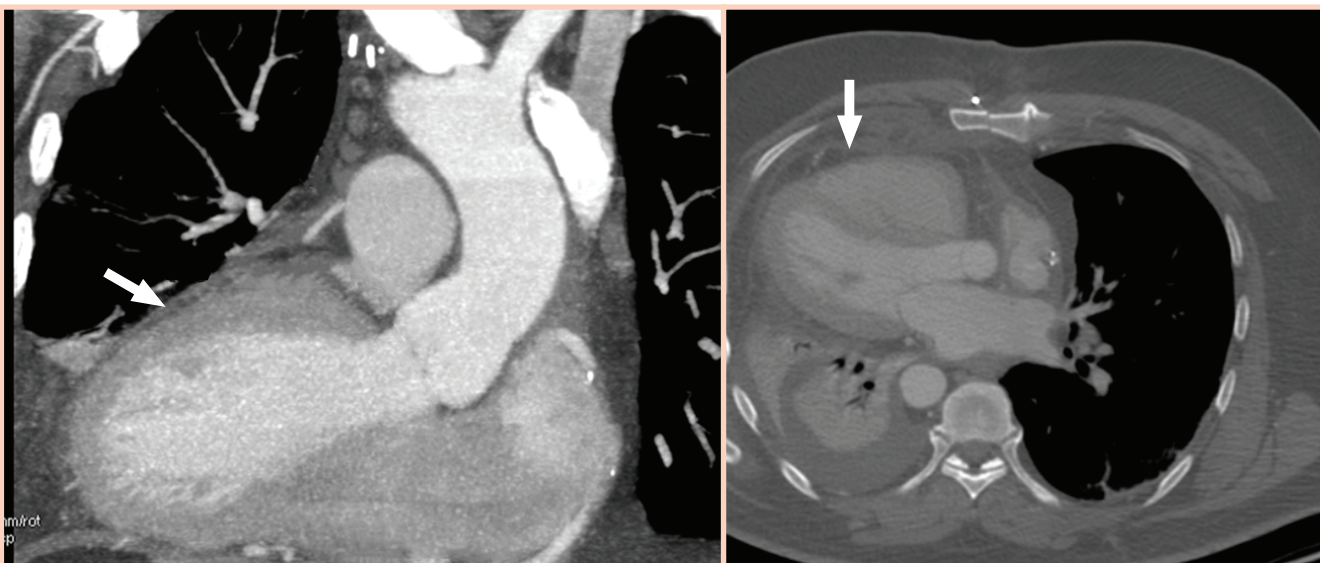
CT image of the left ventricle positioned on the right side of the chest (white arrow).
